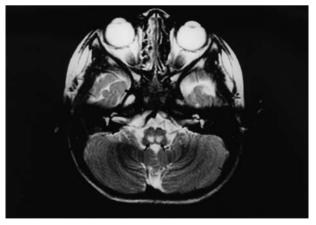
Coronal section of the brain MRI of case 4 (TR:4000, TE:94.8/Ef).
